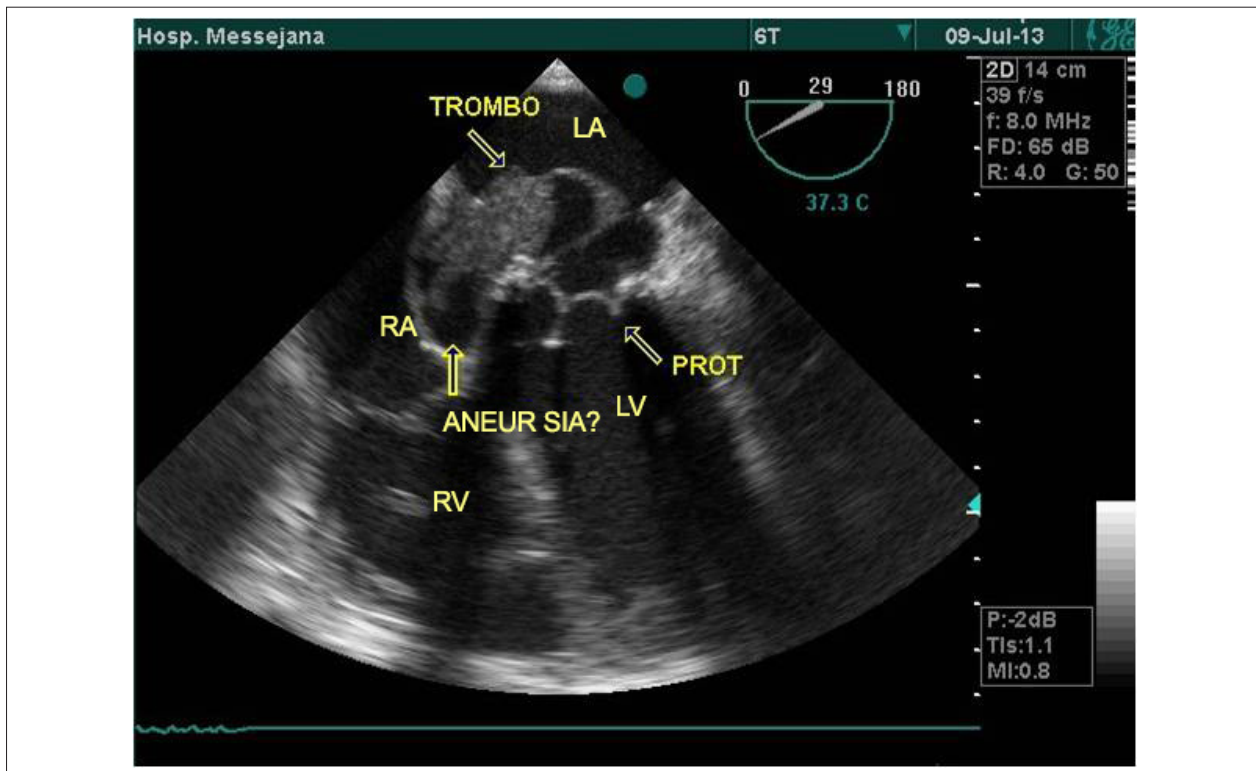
Presence of left atrial thrombus and interatrial septal aneurysm on transesophageal echocardiography.
